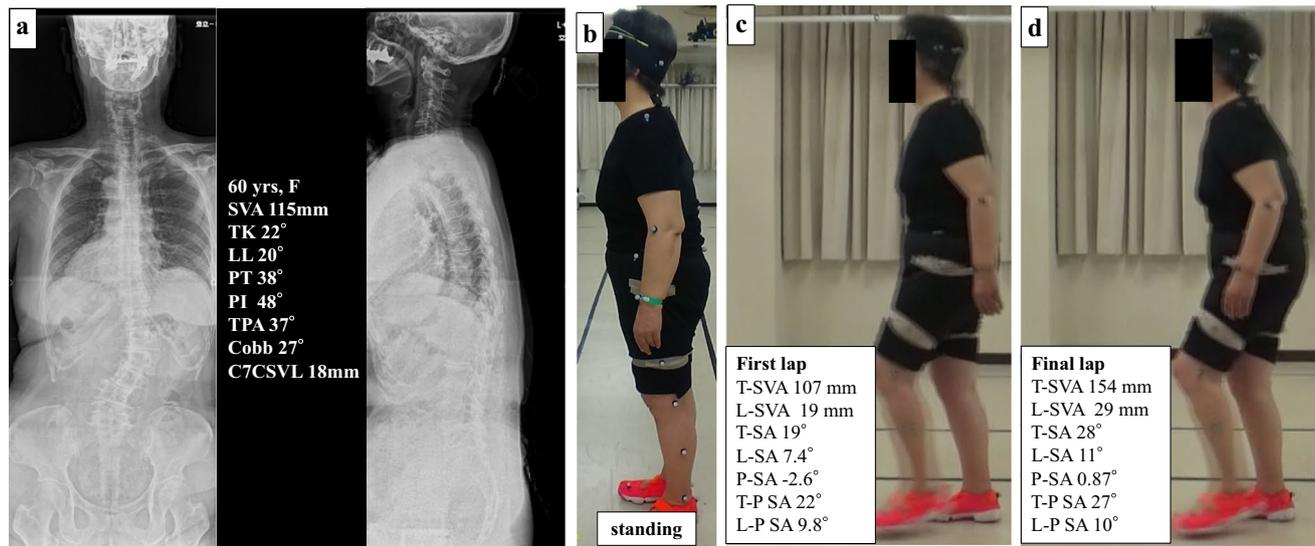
An example of typical sagittal spinal balance change while walking. a Whole-spine radiograph with the patient in a standing position showing typical degenerative lumbar kyphoscoliosis. b Lateral posture on standing. c Lateral posture during 3D gait motion
